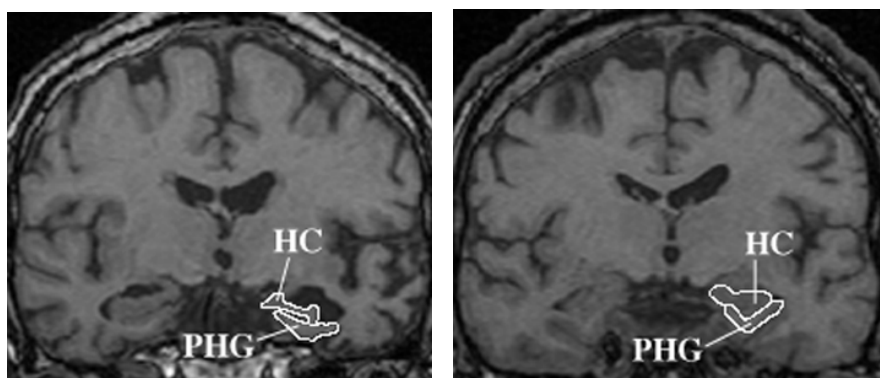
The left image shows the MRI scan of a 69 year old subject with AD at follow-up. The delayed recall z-score declined at follow-up from -1.50 to -2.30. The hippocampus (HC) z-score in this subjects was -0.62, the parahippocampal gyrus (PHG) z-score -1.28, and the MTA score 2 at baseline. The right image shows the MRI scan of a 61 year old subject who had at baseline a similar degree of delayed recall impairment (z-score -1.60). His memory impairment, however, improved at follow-up (delayed recall z-score -0.12) The hippocampus z-score at baseline in this subject was -0.29, the parahippocampal gyrus z-score 1.41, and the MTA score 0.
